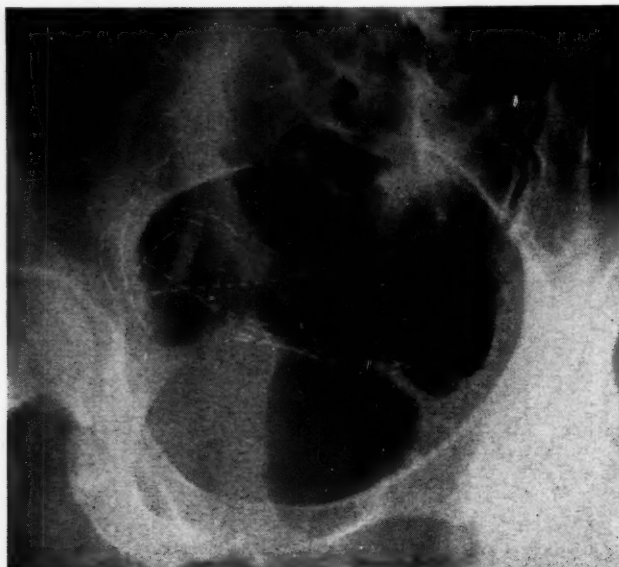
Oblique x-ray of pelvis with threads in place. Aluminum spacers do not show in film.
